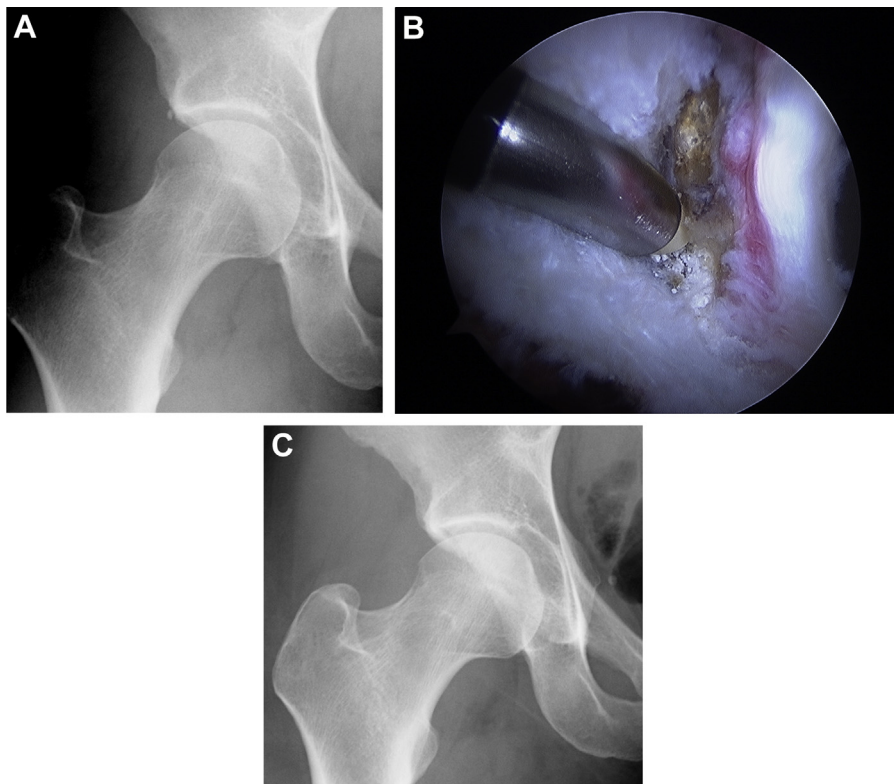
(A) Preoperative standing anteroposterior (AP) radiograph of the right hip with labral calcification. (B) Intraoperative photograph of the labrum of right hip, viewing from the peripheral compartment. The calcium deposit is being expressed from the labrum at the capsule-labral recess. (C) Postoperative supine AP radiograph of the hip showing that the calcification has been successfully removed by arthroscopy.
